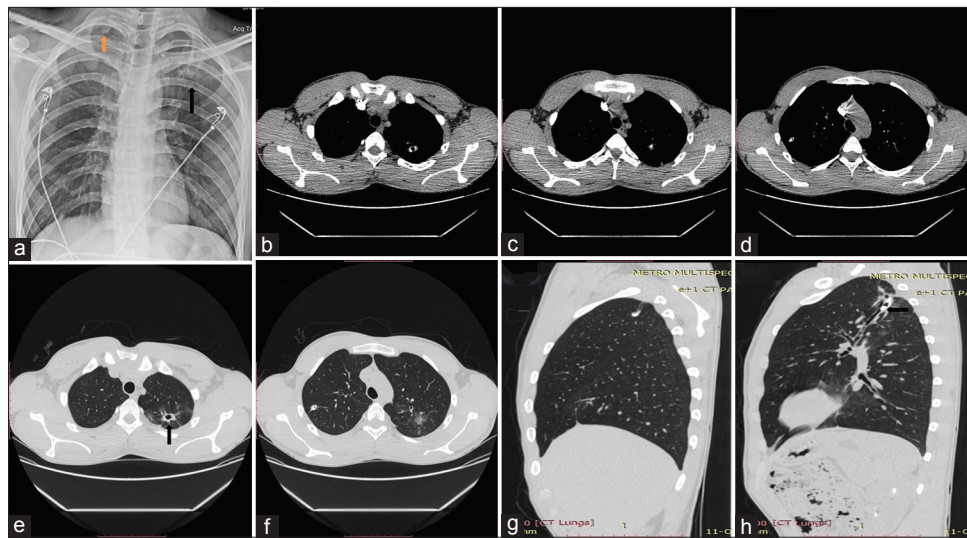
(a) Chest skiagram revealed haziness in right (yellow vertical arrow) and left (black vertical arrow) upper lobes. (b-f) High-resolution computed tomography thorax showed small area of cavitation with calcification in apical segment of the right upper lobe as well as apicoposterior segment of left upper lobe along with surrounding ground-glass opacity seen exclusively in the left upper lobe (black vertical arrow in e) suggestive of active source of bleeding. (g and h) The presence of calcified opacity likely broncholith (black horizontal arrow in h) in dilated bronchi communicating with cavity of left upper lobe especially observed in sagittal section
